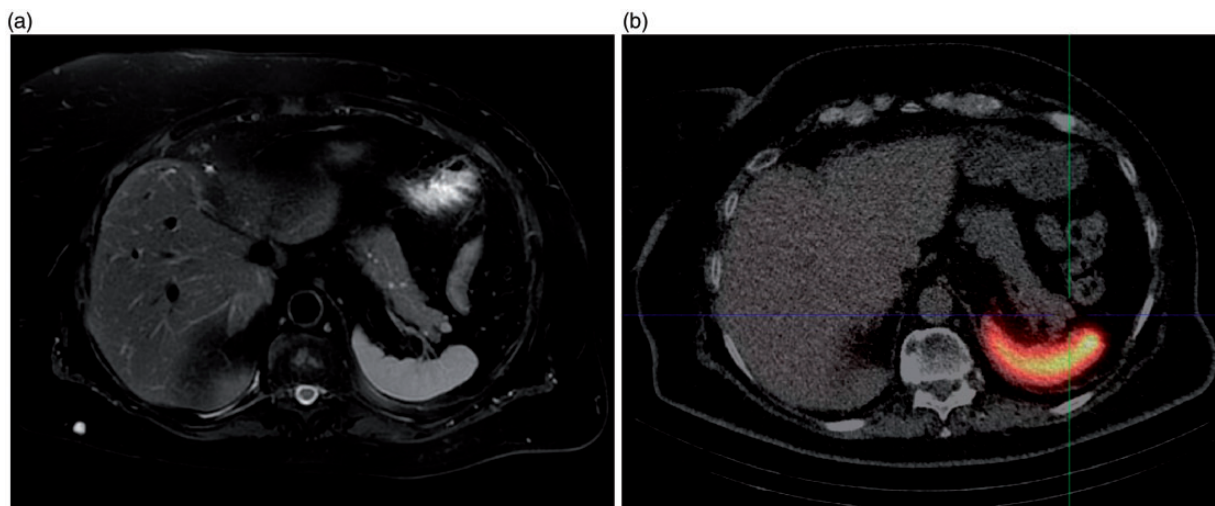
(a) T2 fat-saturation MRI sequence with the intrapancreatic process of similar intensity to that of the spleen. (b) The negative spleen-SPECT of the intrapancreatic process due to its small size.
